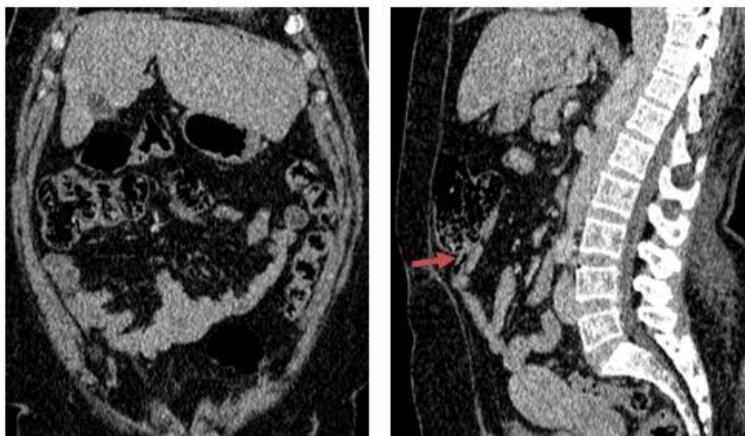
Contrast enhanced CT in coronal and sagittal sections showing Incomplete common mesentery, mobile cecum due to lack of attachment of Todt's fascia and an elevated appendix from its usual anatomical placement (red arrow)
